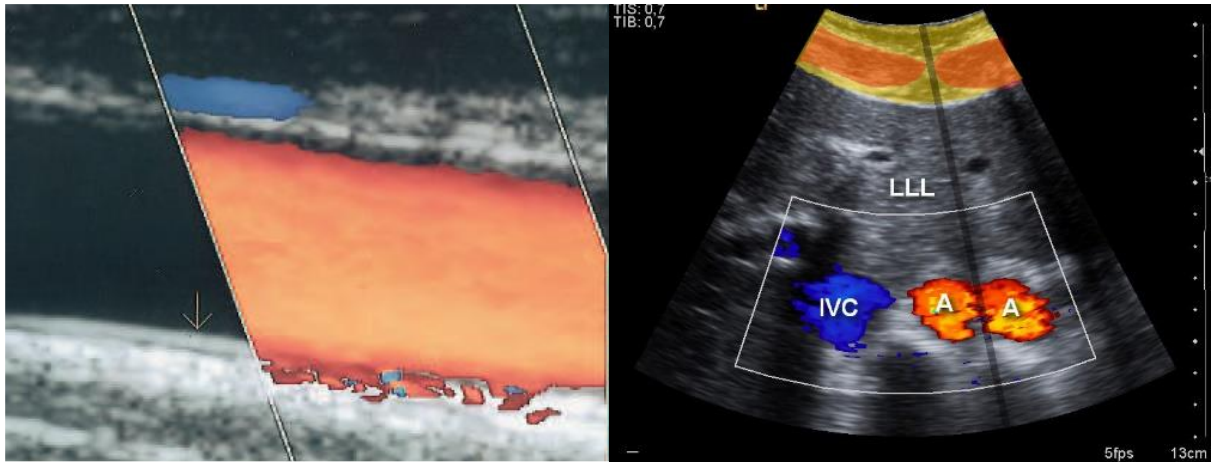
The “bleeding out” of the vessel colour image artefact and the “doubled aorta” artefact in sonography. (88)
